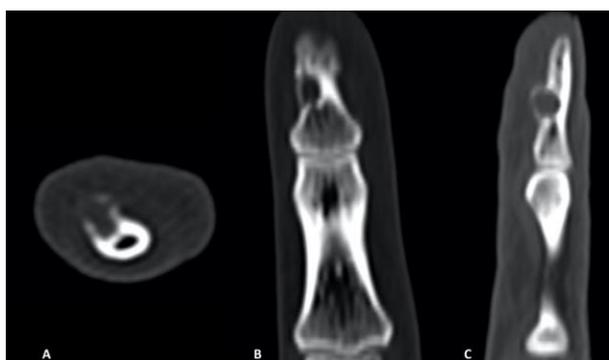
CT of the second finger of the right hand: axial (A), coronal (B) and sagittal (C) reconstructions. The finding is a 5 x 4 x 4 mm solid mass with bone cortical interruption, without periosteal reaction and marrow invasion.
